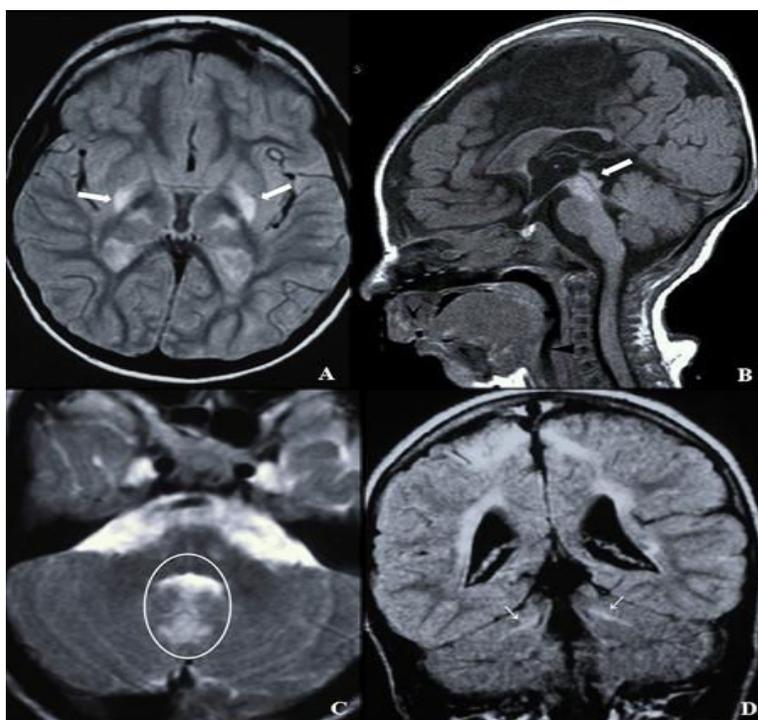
Examples of brain MRI in newborns with more severe HIE. In patients with more severe HIE (Patient No. 12), the abnormal signal extension increases in the thalami and basal ganglia, particularly in the globus pallidus region (Panel A, axial
